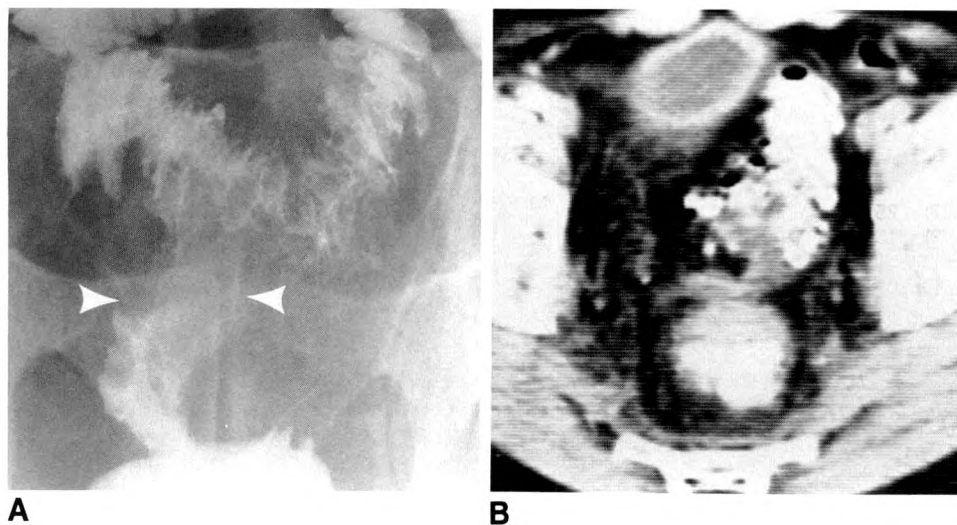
Indeterminate contrast enema/CT.
